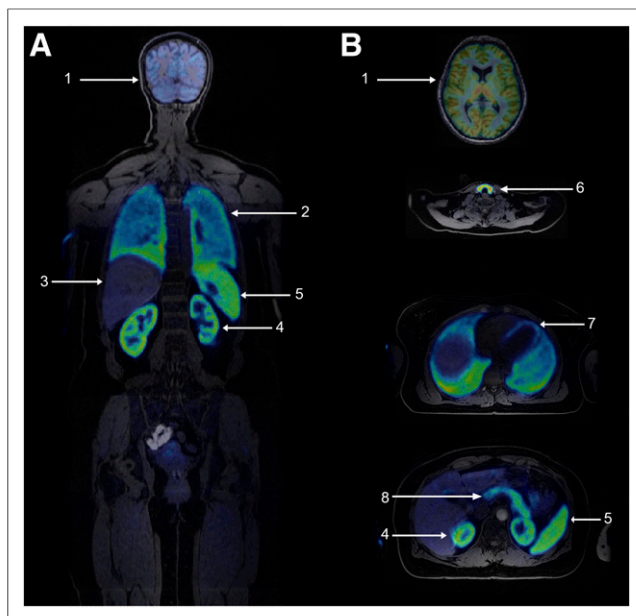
Simultaneous PET/MRI in coronal (A) and transverse (B) planes showing uptake in principal organs 30 min after ^{18}F -FTC-146 injection in subject 10: brain (1), lungs (2), liver (3), kidneys (4), spleen (5), thyroid (6), heart (7), and pancreas (8).
